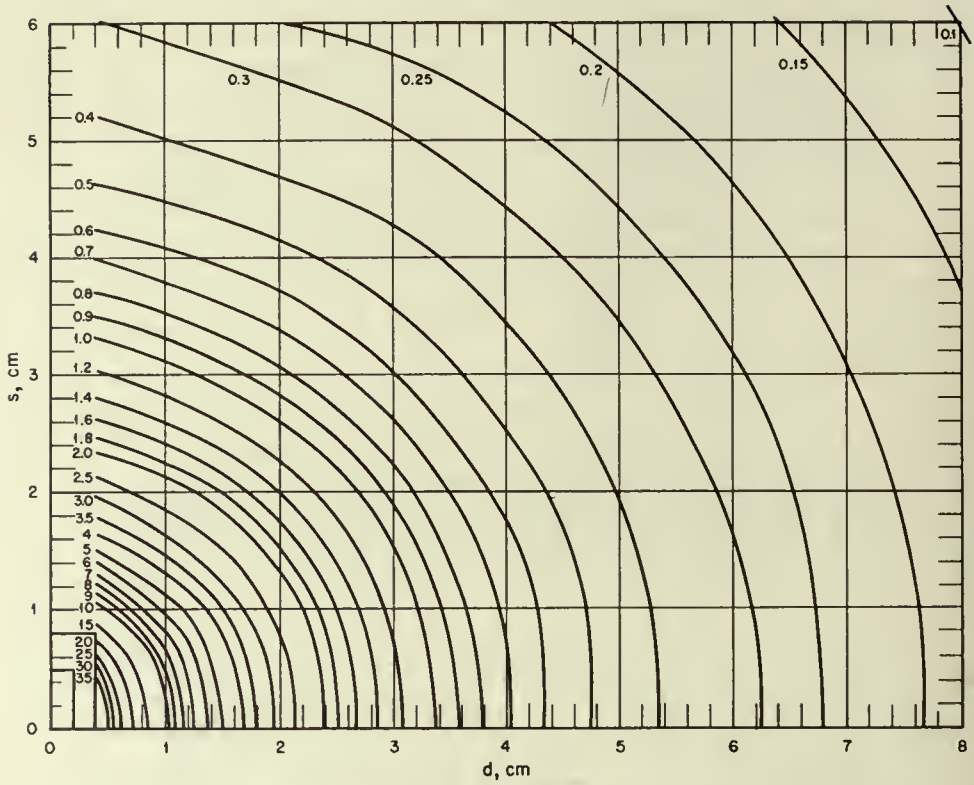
Isodose curves for the axial Co^{60} segments used in the tandem. Rates are given in roentgens per millicurie-hour.
